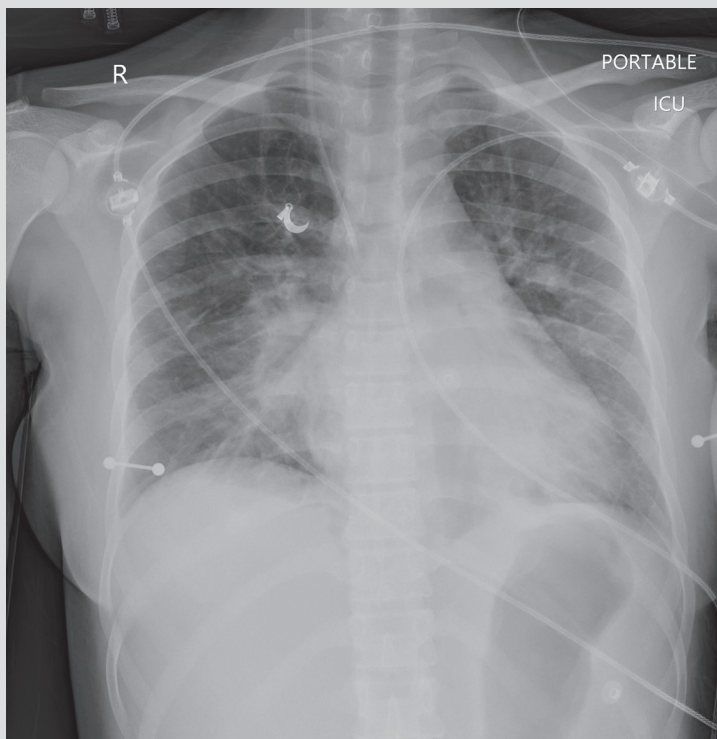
Chest x-ray showing bilateral patchy infiltrates
